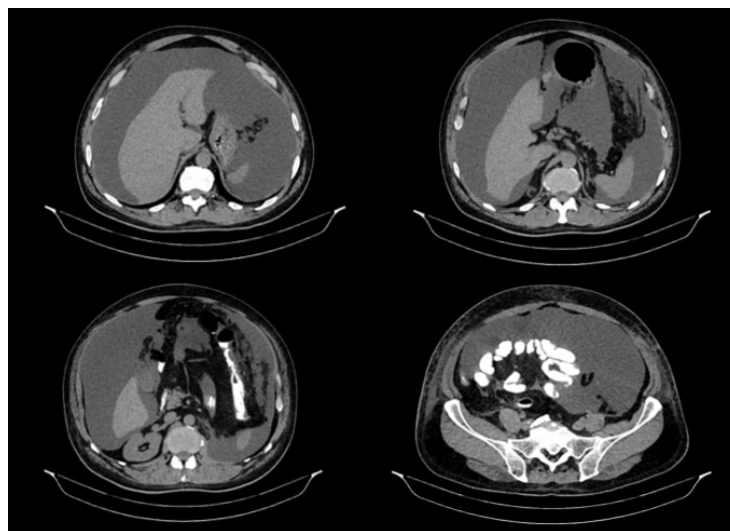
CT image of diffuse intraabdominal fluid at various levels in transverse section.
